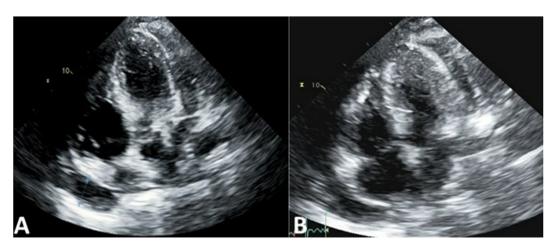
Transthoracic echocardiogram demonstrating a moderate-large pericardial effusion with tamponade physiology (A and B).
